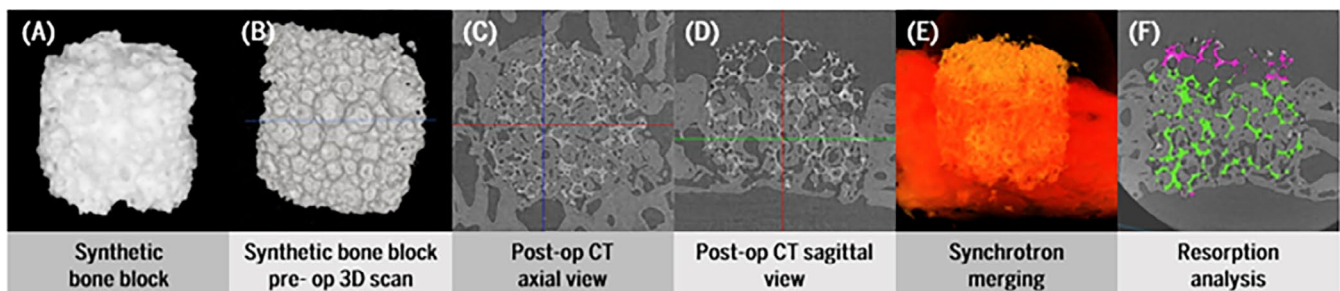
Representative images of synchrotron observation. (A) Preoperative synthetic bone block. (B) 3D scan of the preoperative synthetic bone block. (C) Postoperative CT view (axial). (D) Postoperative CT view (sagittal). (E) Merged preoperative and postoperative scans. (F) Resorption analysis, showing intrabony (green) and extrabony (pink) areas, separately.
